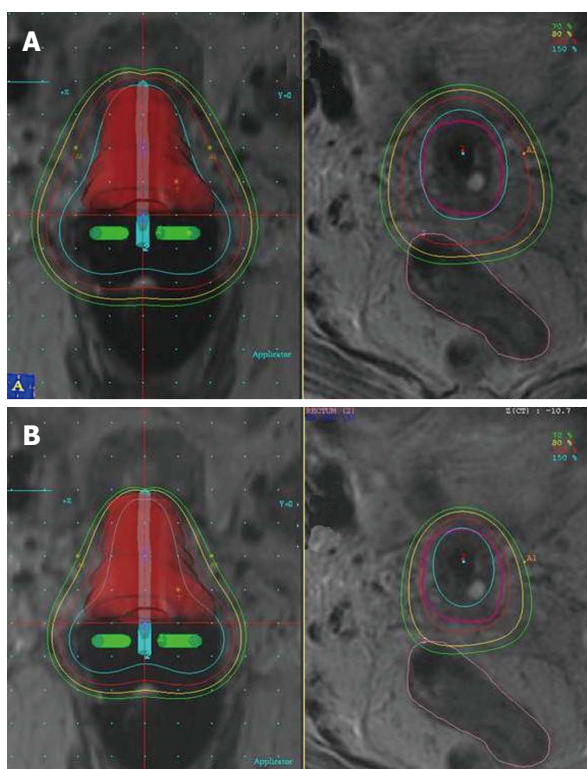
Sigmoid colon sparing with image-based planning. Magnetic resonance imaging planning images showing point A optimized plan with high doses to adjacent sigmoid colon (A), which is reduced with image-based 3D optimization (B).
